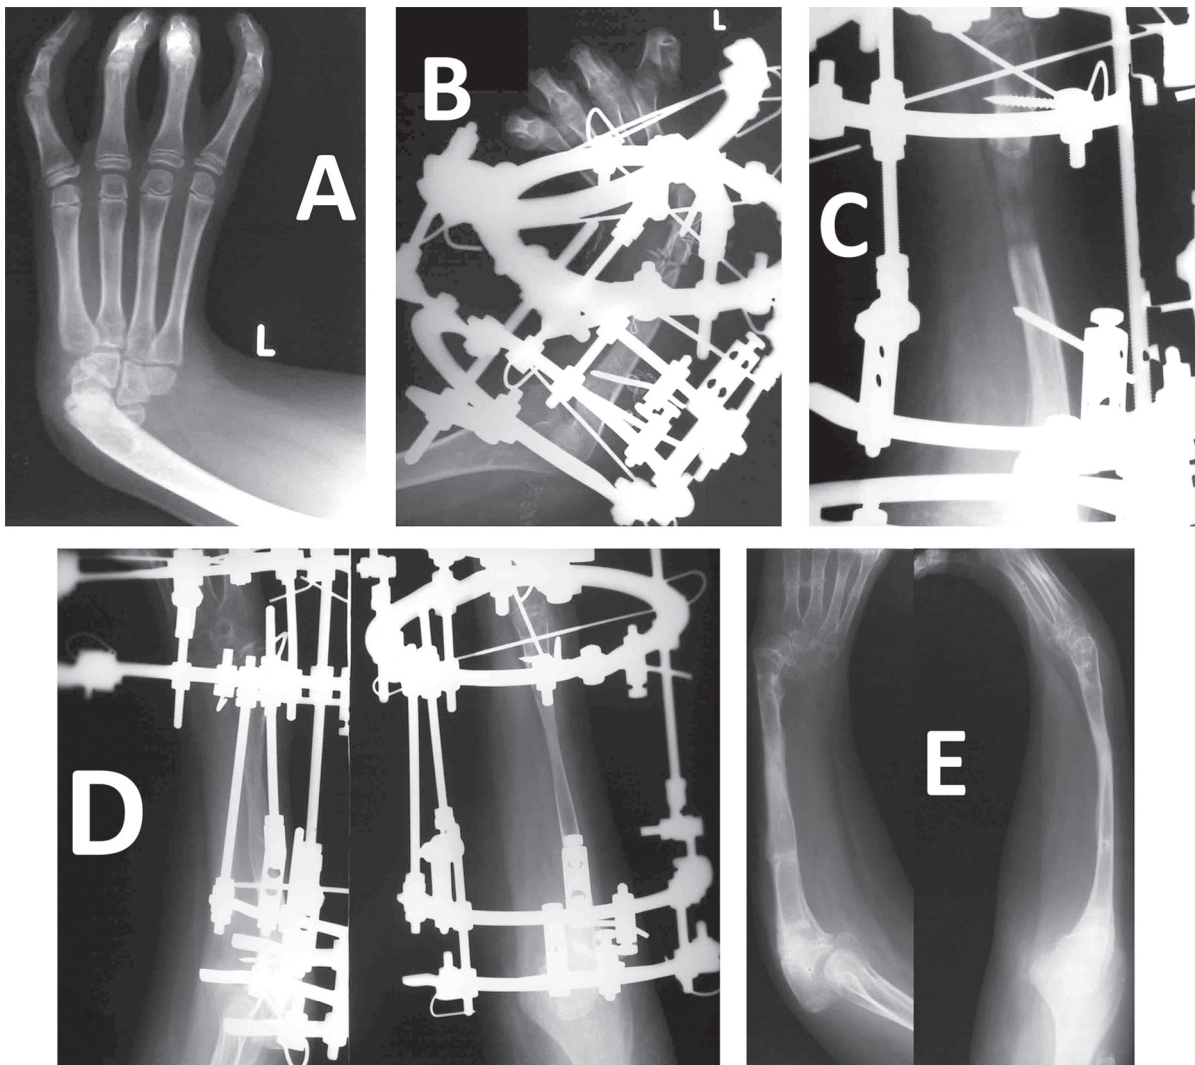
Radiographs of a case treated by ulnar lengthening and gradual correction of wrist deformity: A – preoperative radiograph; B – immediate postoperative radiograph; C – during distraction with regenerate formation; D – after consolidation; E – at one year of follow-up
